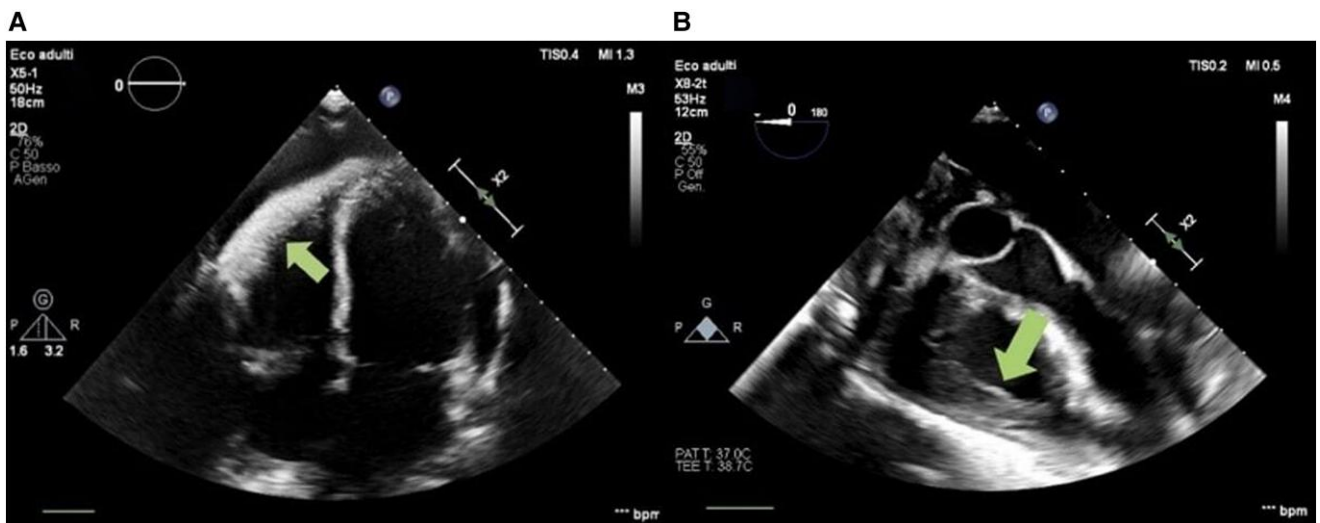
Transthoracic at apical four-chamber view (A) and transoesophageal at mid-oesophageal four-chamber view 0-degrees (B) echocardiogram showed abnormal right ventricular thickening (arrows).
